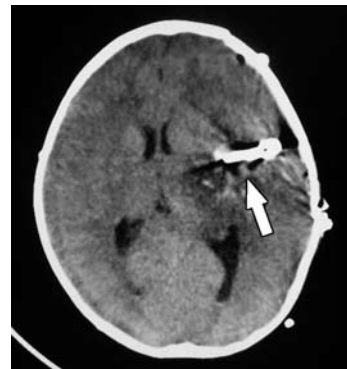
Post-operative CT scan demonstrating the successful evacuation of the intracerebral hematoma and clipping of the left middle cerebral artery aneurysm. Some ischemic changes are noted in the left sylvian region and temporal lobe.
